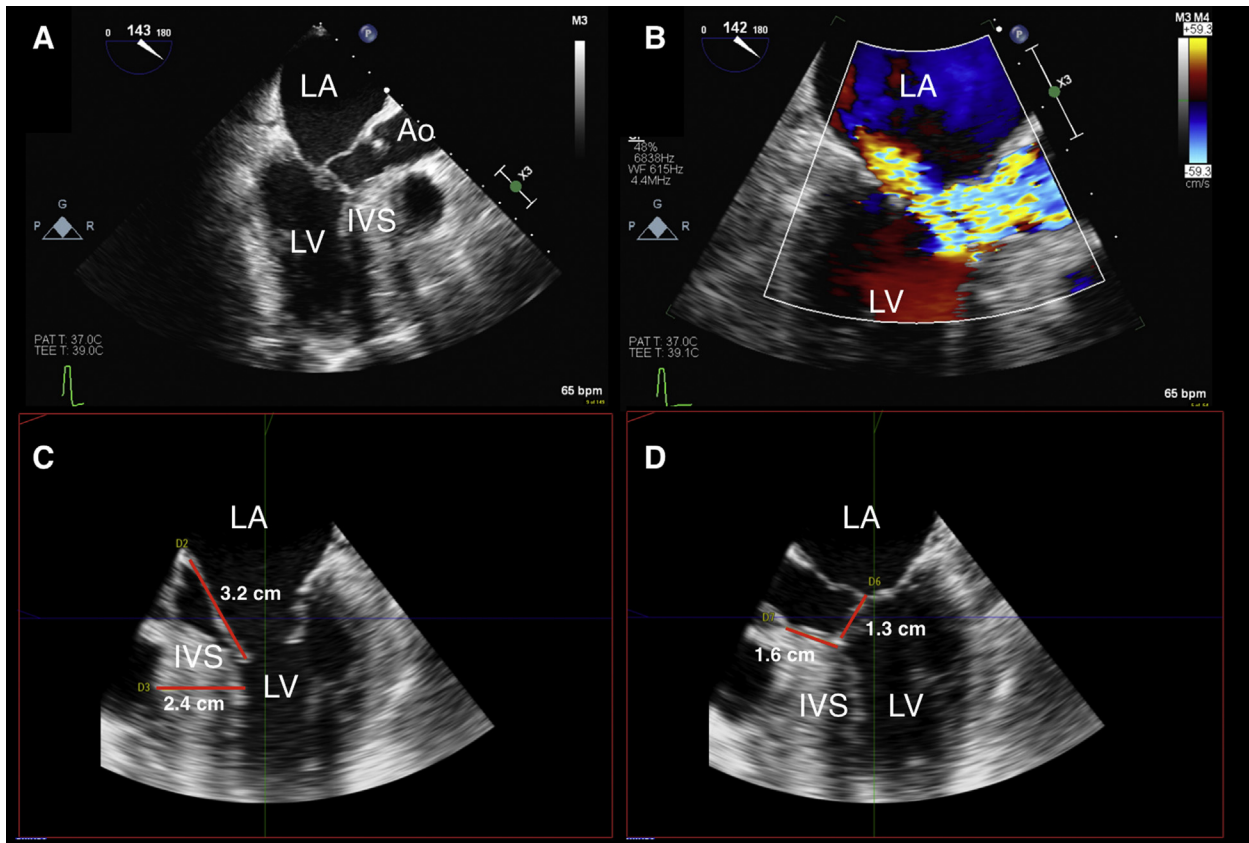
(A) ME LAX view showing systolic anterior motion of the mitral valve, the anterior leaflet (AL) making contact with the inter-ventricular septum (IVS). (B) ME LAX view with color flow Doppler showing posteriorly directed mitral regurgitation, and flow acceleration in the left ventricular (LV) outflow tract, which seems to originate at the level of contact of the mitral valve with the IVS. (C) Measurements of the IVS maximum thickness (2.4 cm) and AL length (3.2 cm) performed using multiplanar reconstruction of a 3D data set. (D) Measurements of the redundant length of the AL beyond coaptation (1.3 cm) and the distance from the aortic annulus to septal contact (1.6 cm) performed using multiplanar reconstruction of a 3D data set. Abbreviations: Ao, Ascending aorta; LA, left atrium; LV, left ventricle.
